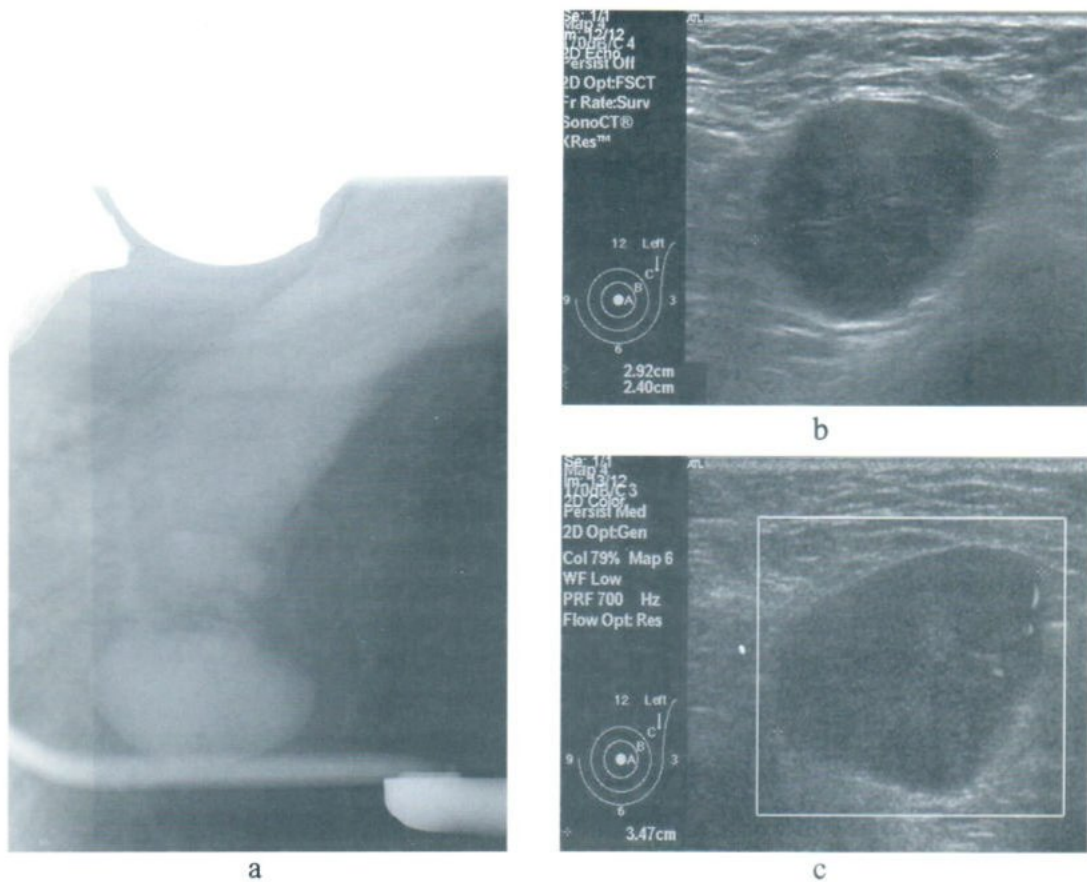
Enlarged dense axillary lymphadenopathy in mammography (a), and a round-shaped node form ultrasonography (b), and hypervascularity from Doppler study (c)
